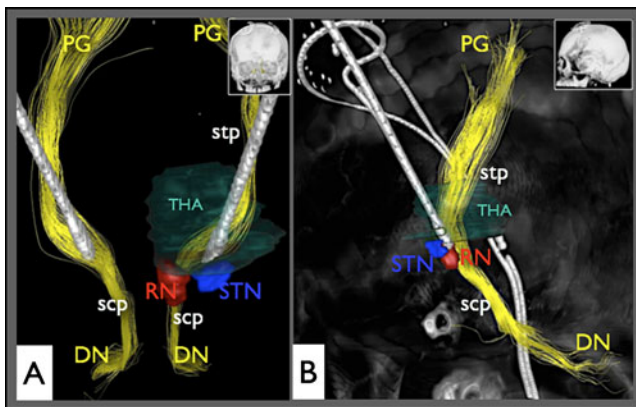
Three-dimensional depiction of DBS electrode positions (from CT) and anatomical structures (from MRI). Note how DBS electrodes traverse the thalamus to reach the subthalamic level. Detailed anatomy is shown on the left side only for better overview. A Frontal view; B lateral view. Lack of crossing of the drts under the RN level is due to limitations of the fiber tracking technique. Abbreviations: Same as in Fig. 2. DN=dentate nucleus, PG=precentral gyrus, scp=superior cerebellar peduncle, stp=superior thalamic radiation, THA=thalamus
